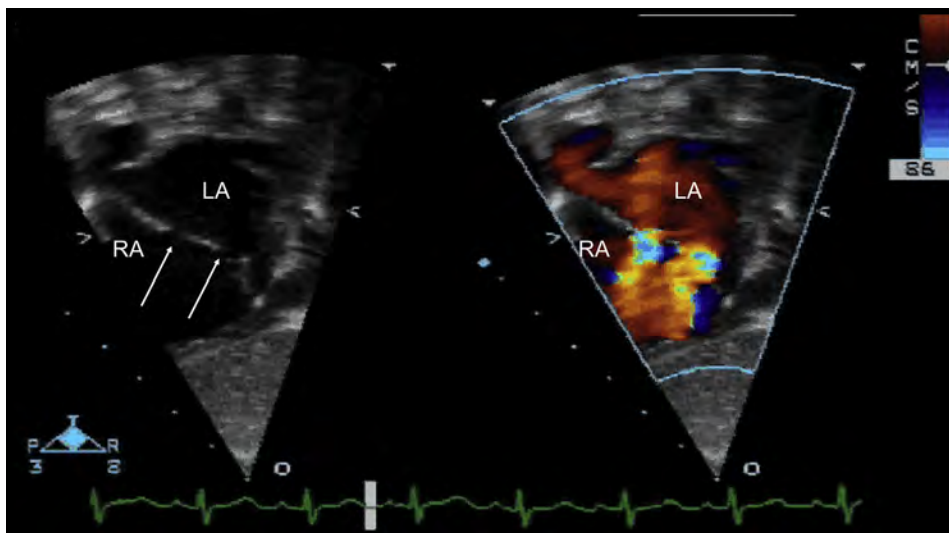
Subxiphoid TTE demonstrating multifenestrated IAS without and with color Doppler flow from left to right in a pediatric patient. See also [Video 5](#).
